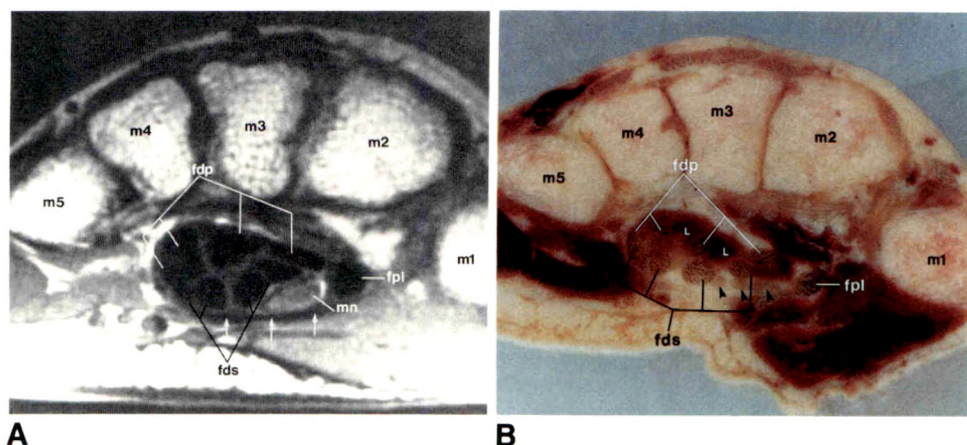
Axial MR image (TR 600, TE 25) (A) and anatomic section (B) at level of metacarpal bases. Right wrist viewed toward elbow with palm down. On MR image, median nerve has begun to thin but has not yet branched. On anatomic section, median nerve has divided into its three terminal divisions (arrowheads). Note origins of lumbrical muscles on anatomic section (arrows). Flexor retinaculum (arrows). (See key for abbreviations.)
